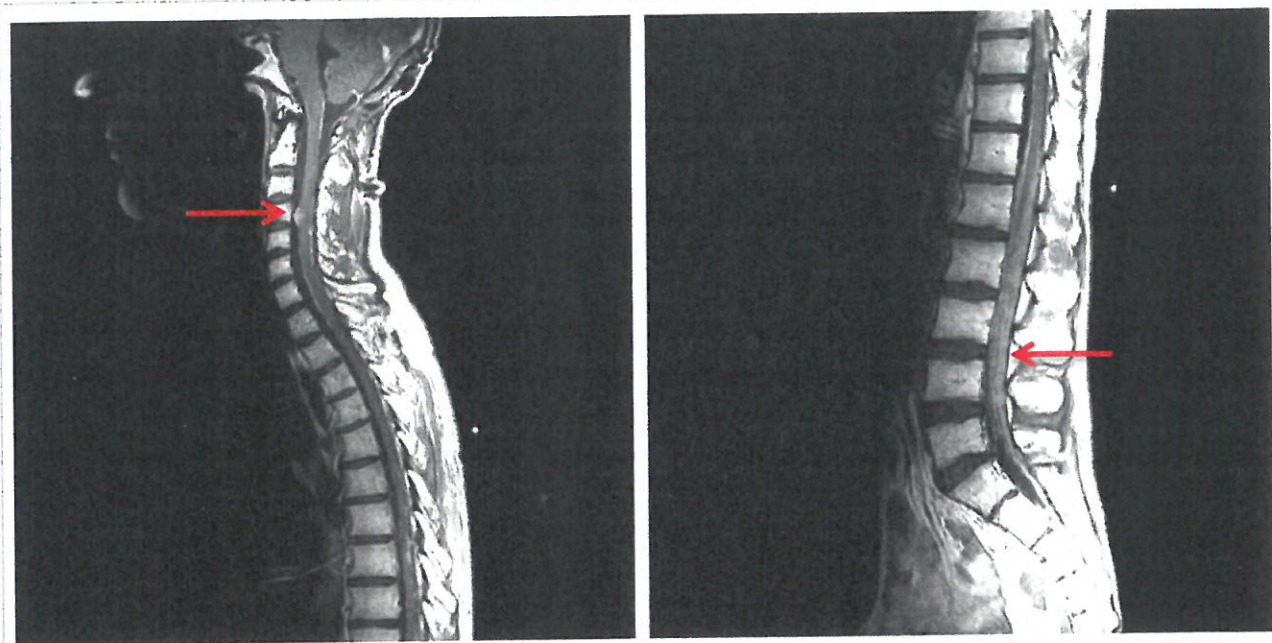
Magnetic resonance imaging of a patient with neoplastic involvement of spinal meninges (images from Medscape.org, 2012).
